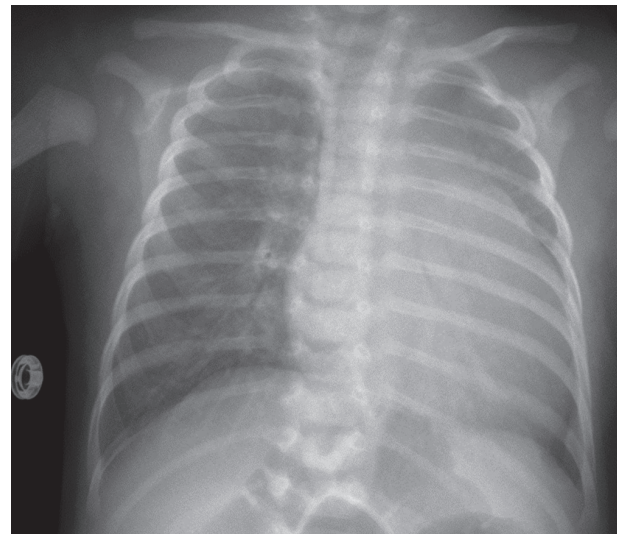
Chest X-ray at admission evidencing very significant cardiomegaly.
